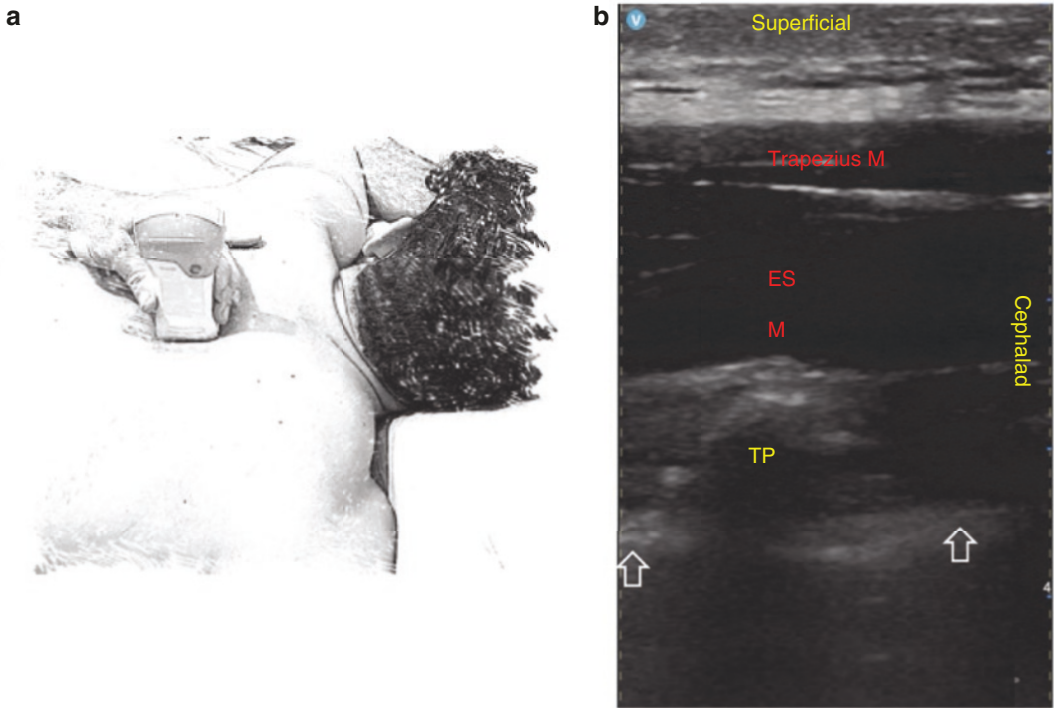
Ultrasound-guided Erector Spine Plane (ESP) block. (a) Position of the ultrasound probe for the thoracic ESP block. Blue dot is the location of the needle approach.
